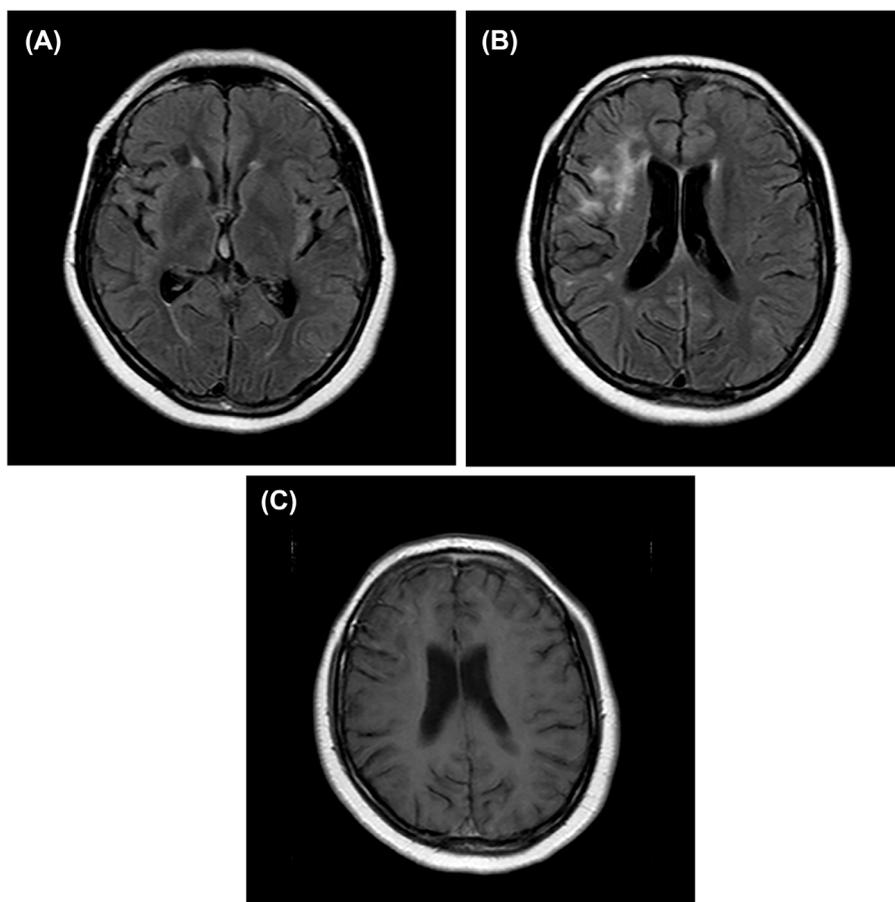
Non-contrast axial FLAIR (A and B) MRI showing partial resolution of demyelinating lesions, with remaining white matter hyperintensities in frontal and parietal lobes. Axial T1-weighted image showing no gadolinium enhancement (C).
